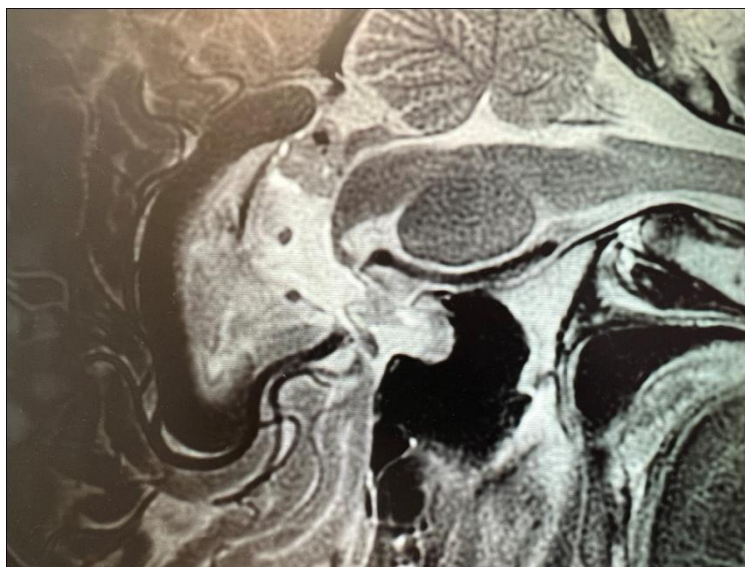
MRI scan of the head (sagittal section of the brain) pineal gland – pinealoma.
